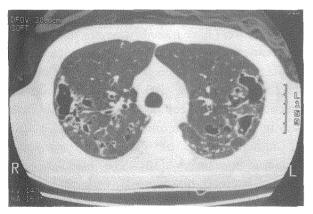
Chest CT reveals diffusely distributed cystic lesions, and thin-walled cavitary nodules, which are more prominent in the upper lobes.
